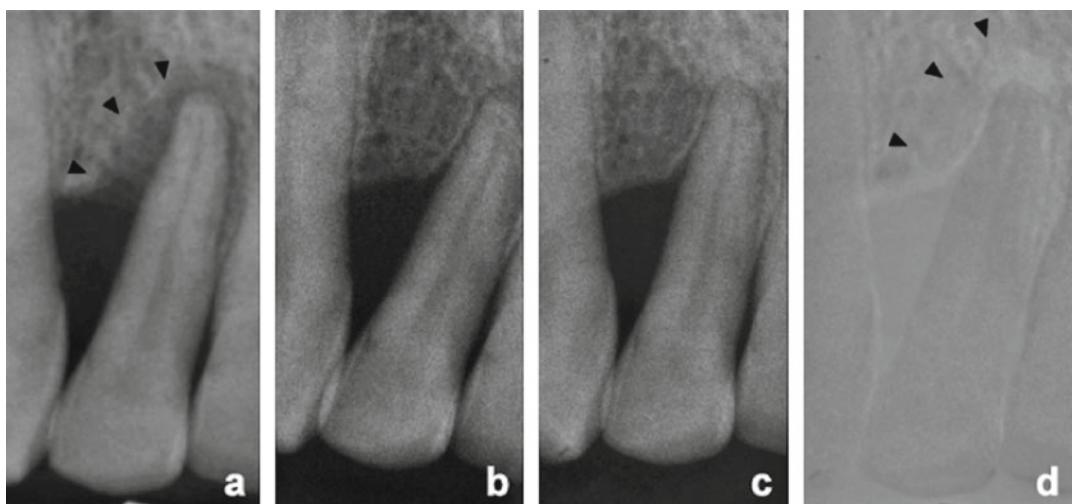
Radiographically visible healing results in a deep intrabony defect at a maxillary right lateral incisor treated with the control Poly(lactic acid) membrane (same patient as in Fig. 12.4): (a) intrabony defect (*arrows*) at baseline; (b) after 12 months; (c) after 24 months; (d)
